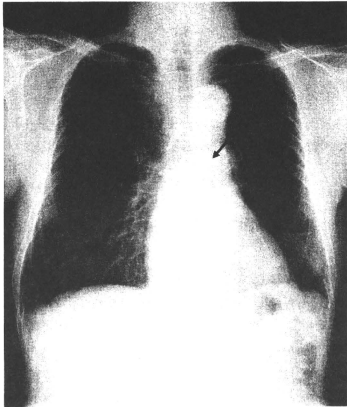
A chest roentgenogram indicating a loss of translucency (arrow) in the left main bronchus, with no chest abnormal shadows in either lung field.
